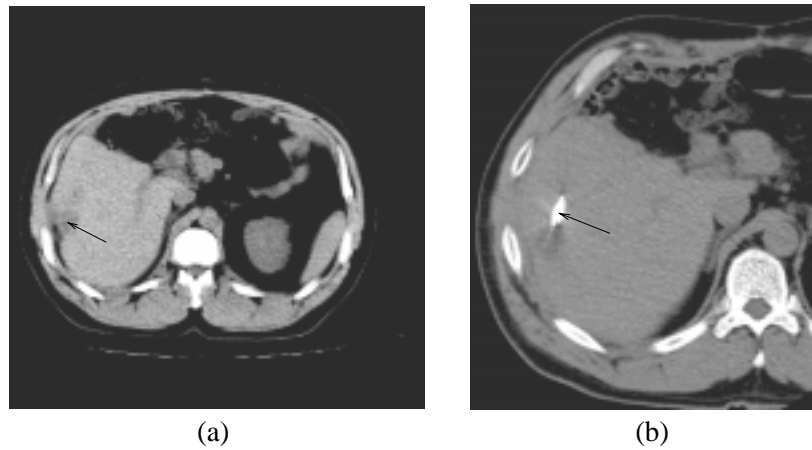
Axial CT slices from percutaneous liver metastases procedure, (a) initial CT scan where arrow shows the position of the target metastasis, (b) CT slice showing the position of the tips of the RF probe (marked by the arrow) Note, because an oblique trajectory was used only a short section of the probe is seen in each axial slice.
